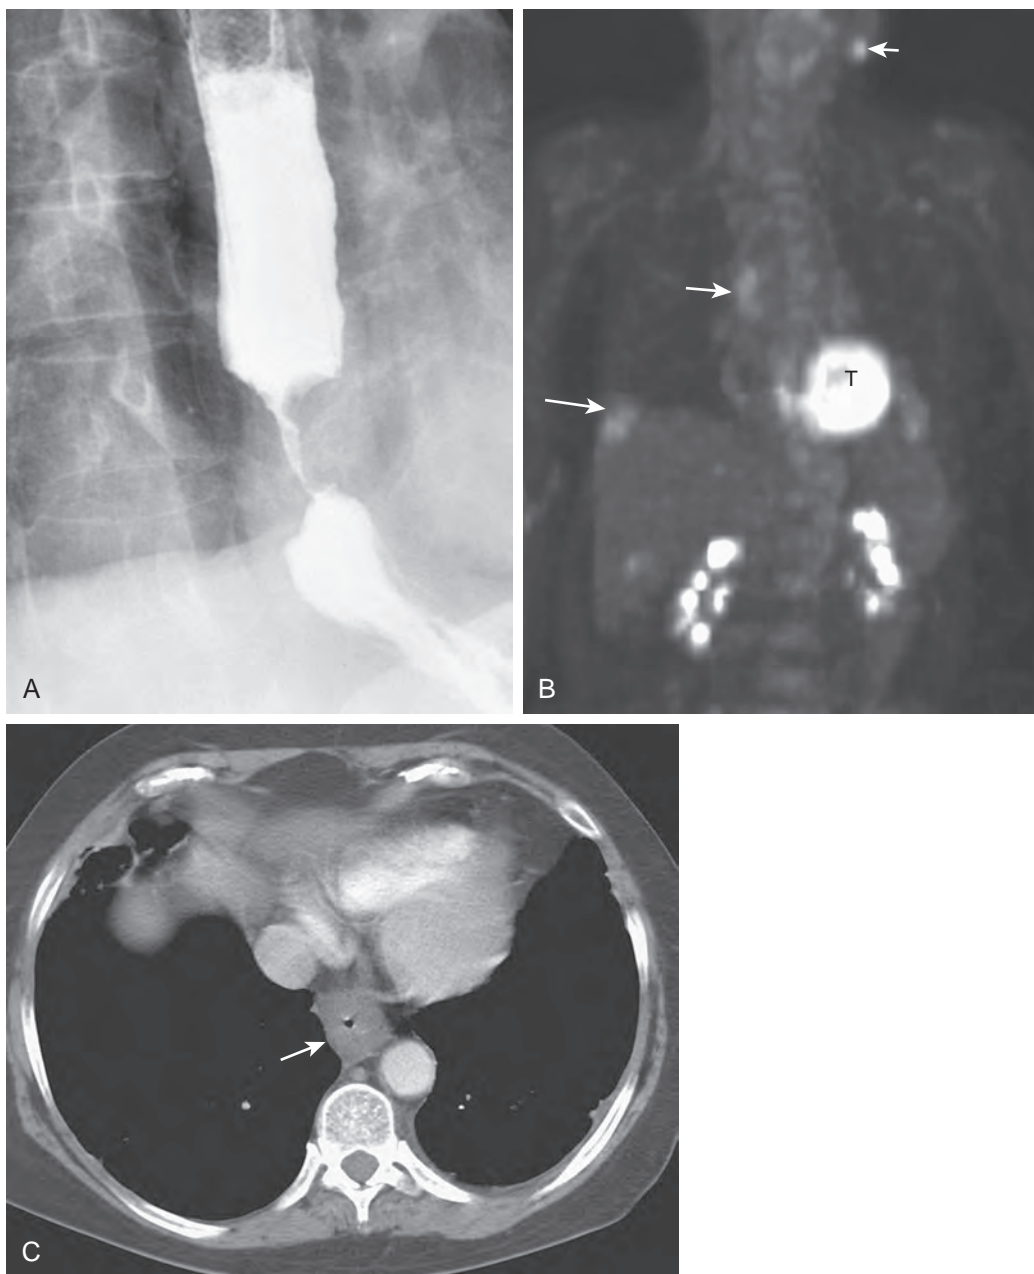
Value of PET for showing metastases not detected on CT scan. A. Barium study shows a circumferentially infiltrating carcinoma of the distal esophagus. B. Coronal PET image shows marked uptake of radionuclide in distal esophageal tumor (T). However, there is also uptake in metastases to the liver (*long arrow*), mediastinum (*medium arrow*), and a left cervical lymph node (*short arrow*). The PET scan has therefore dramatically altered the staging of this patient's disease. C. CT scan shows marked esophageal wall thickening by tumor (*arrow*). However, this lesion is potentially resectable without CT scan findings of local or distant metastases. (Note how there is less than 45 degrees of contact between the tumor and adjacent aorta.)
